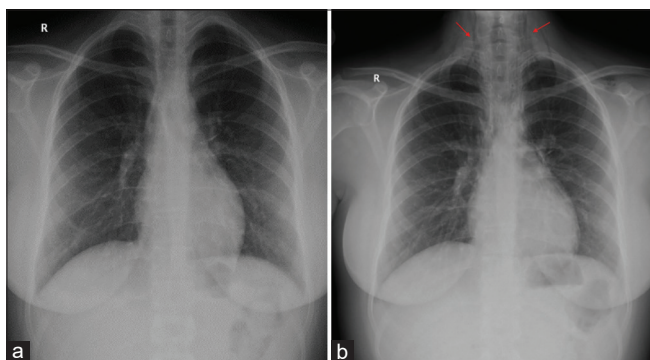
(a) The patient's initially obtained X-ray at admission. (b) The patient's x-ray after re-evaluation after 2 h (arrows pointing the subcutaneous emphysema)
